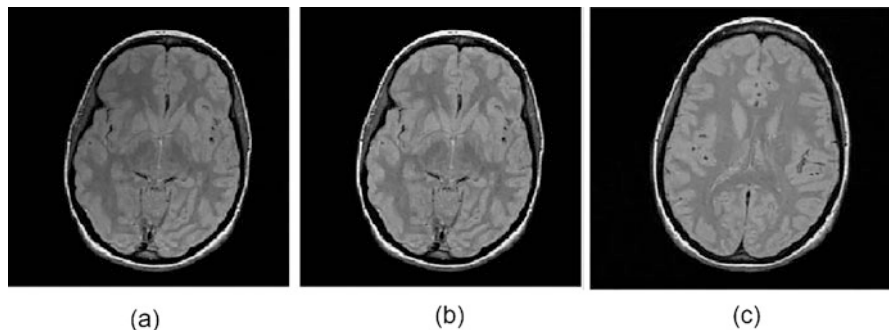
Intensity standardization example. (a) Original MRI slice, (b) Same slice with intensity inhomogeneity correction, (c) Another slice with both intensity inhomogeneity correction and standardization [56]. (Reprinted under Elsevier license no. 5161971050868)
